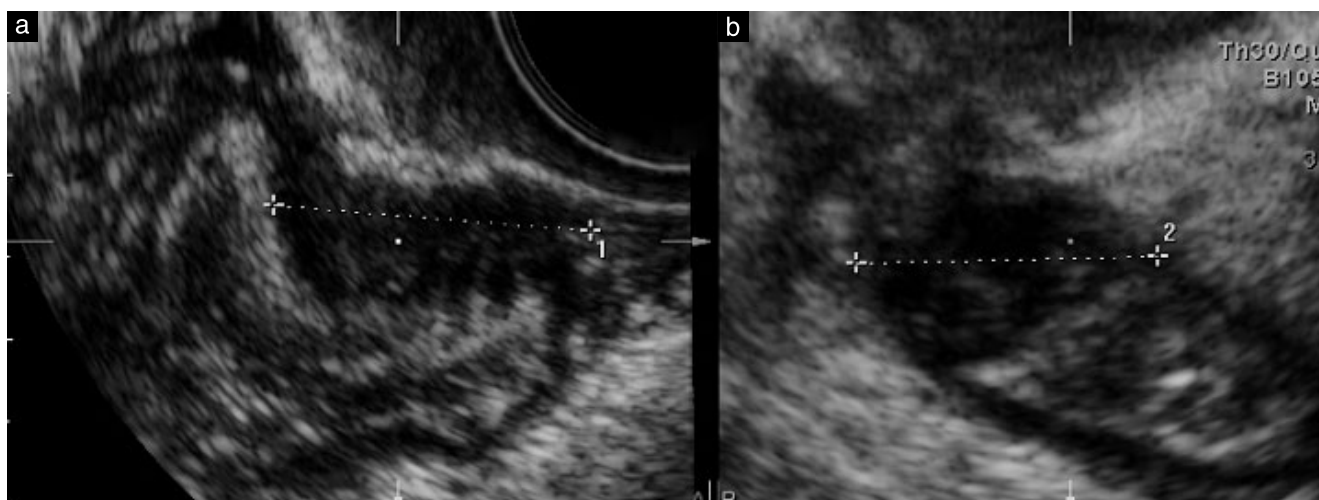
Sagittal transvaginal ultrasound images of the sigmoid colon. (a) Longitudinal section: a hypoechoic nodule with irregular borders is shown (calipers) located on the antimesenteric surface of the bowel. (b) Transverse section at the same level of the nodule.
